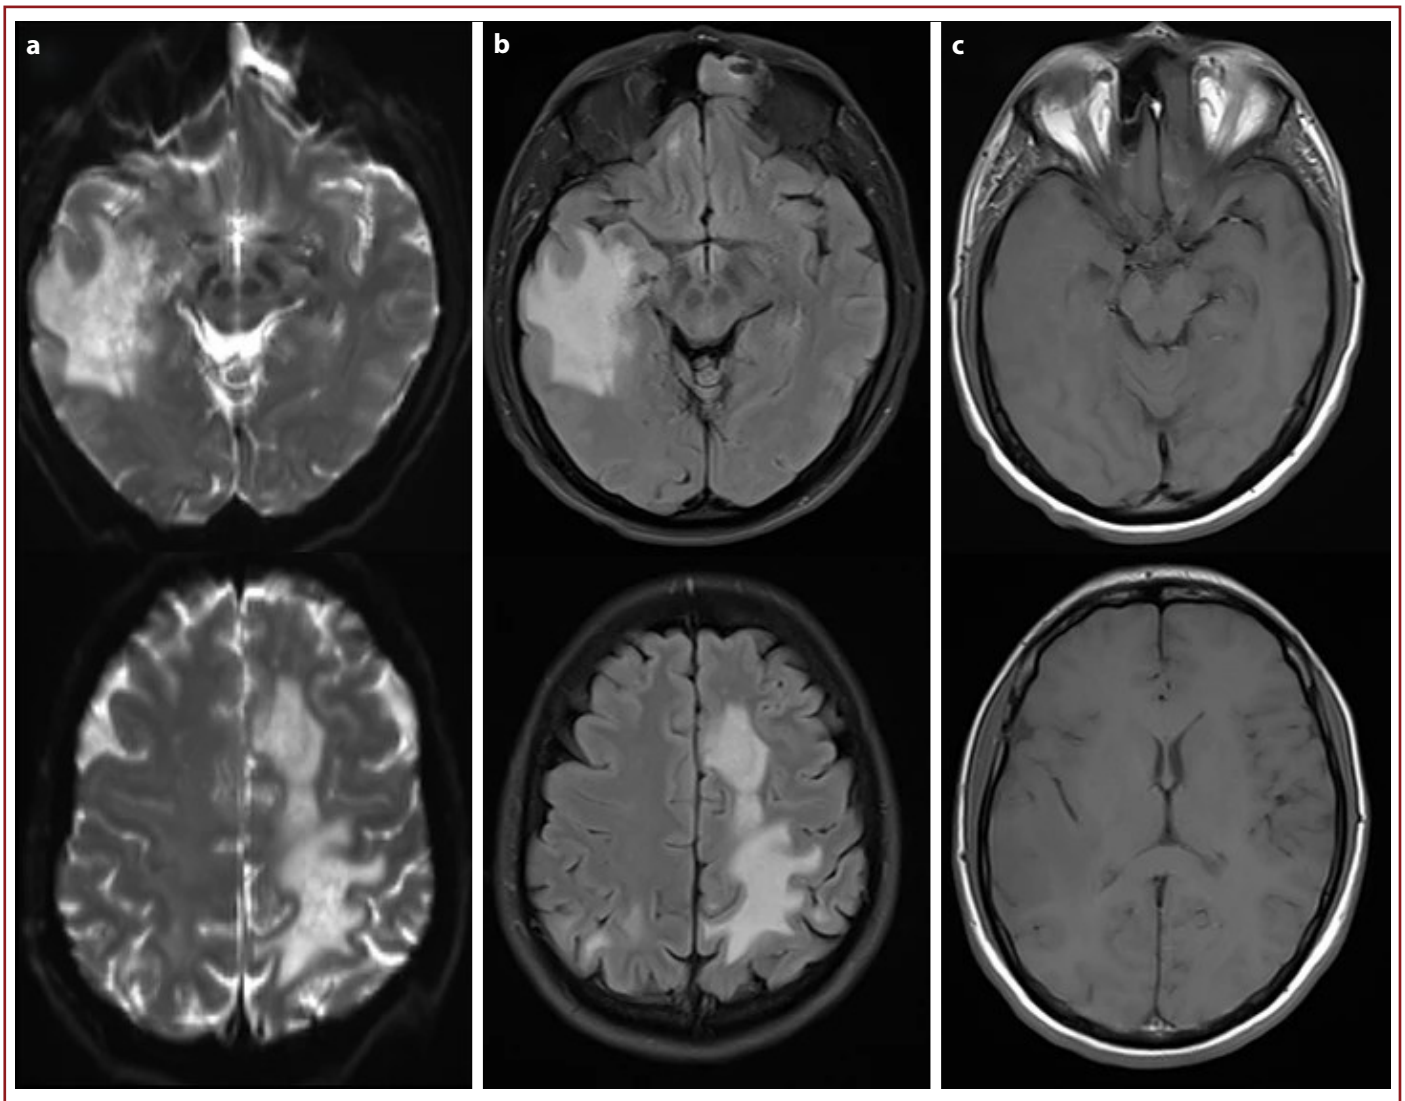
Showing MRI brain axial sequences Diffusion (a) / FLAIR (b) / T1 with contrast (c) at various stages of the patient.
